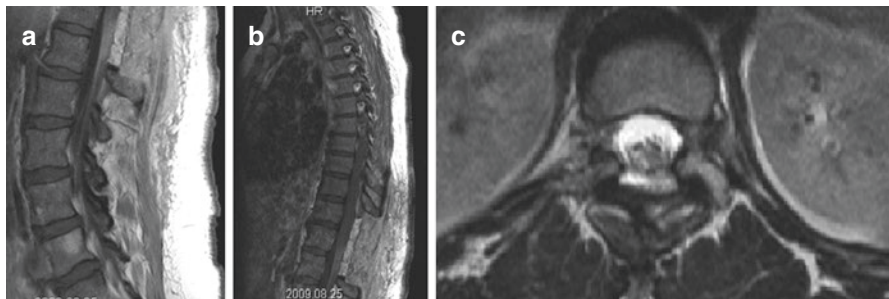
Postoperative MRI of the spine with and without contrast showing the complete lesion resection. (a) T1-weighted post-contrast sagittal MRI of the lumbar spine. (b) T1-weighted post-contrast sagittal MRI of the thoracic spine. (c) T2-weighted axial MRI of the resection cavity at T12
